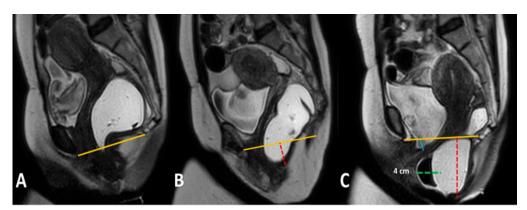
Dynamic T2W MRI images performed in a 47-year-old female patient during pelvic floor muscle contraction (A), flexion (B) and rectal emptying (C). Grade II° descent of the anorectal junction and pelvic floor grade (red dashed line), grade II° anterior rectocele (green dashed line), grade I° cystocele (blue line) are observed. Pubococcygeal line (solid yellow line).
